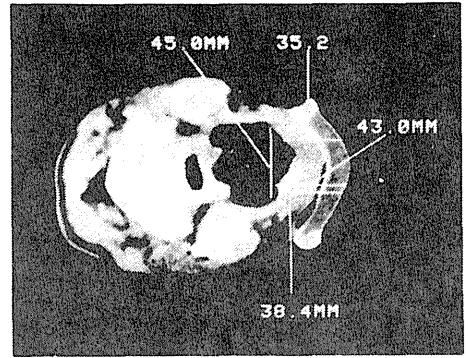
CT view of malignant melanoma metastatic to upperlip.
